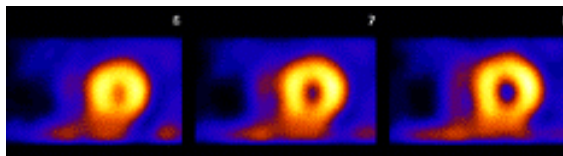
SPECT imagery [Mannting95].
